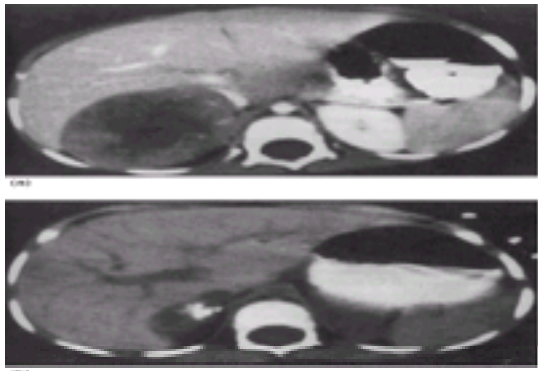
(a) CT scan of a right adrenal neuroblastoma in a 1½-year-old girl presenting with stage D disease. (b) Follow-up study demonstrates marked resolution of the tumor and the development of calcification within the mass.
